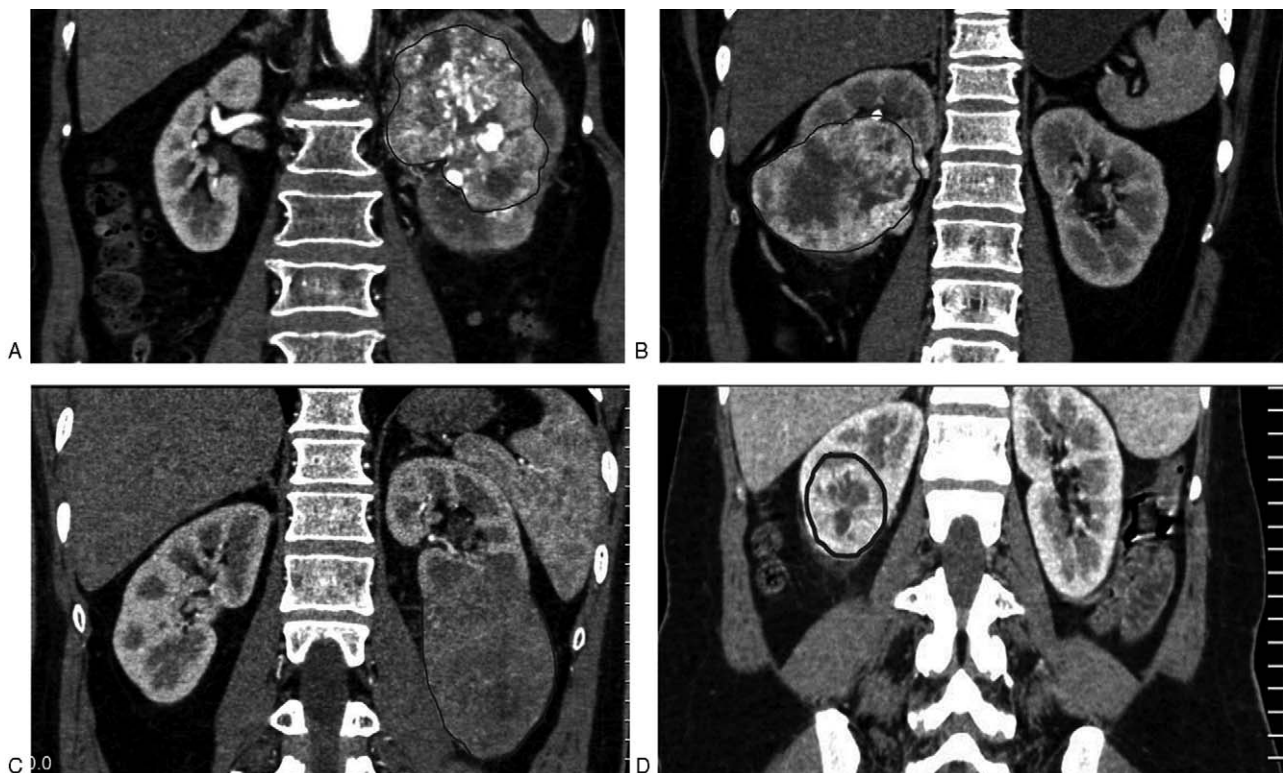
Position of renal cell carcinoma lesions on computed tomography. (A) Central type. (B) Central-exophytic type. (C) Exophytic type. (D) Restricted type.
